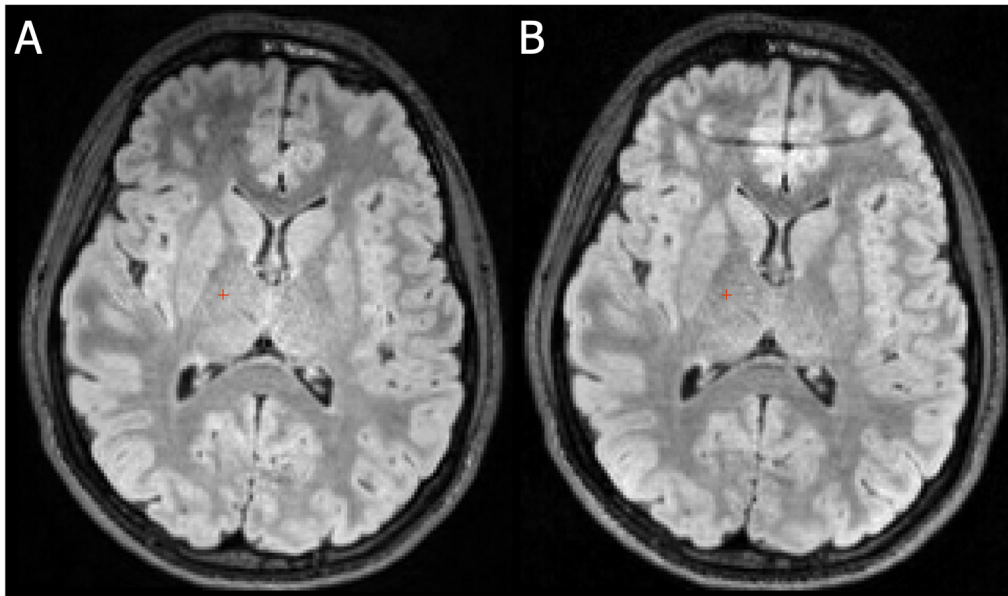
Example of artefact introduced by the retrospective reconstruction algorithm in FLAIR scans. A scan for nodding motion with pMC and reacquisition is shown, which is reconstructed (A) by the scanner and (B) retrospectively.
